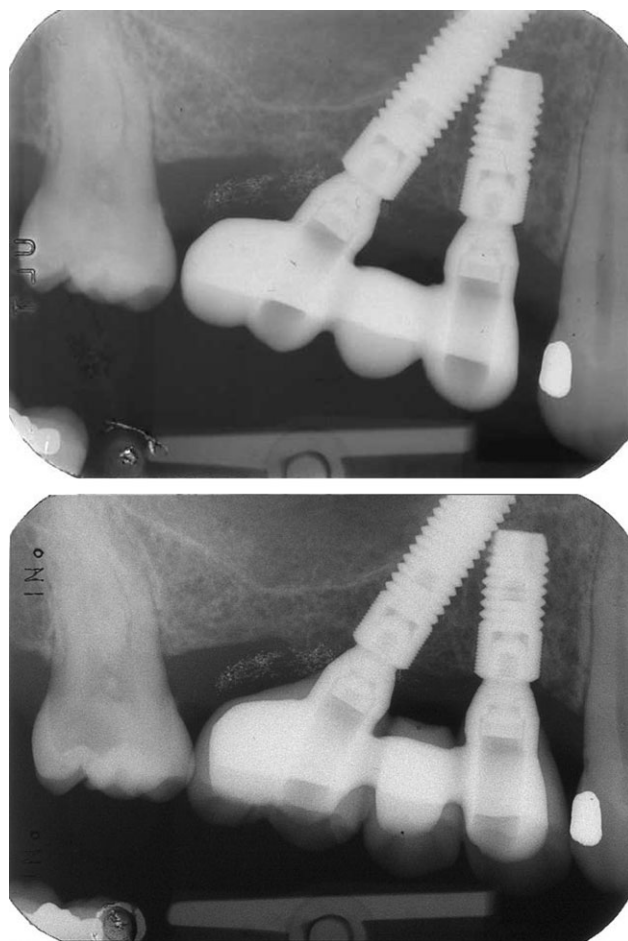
X-rays at try-in of the Cresco framework and after 1 year of loading. A cantilever was used to create the contact point with the second molar.
